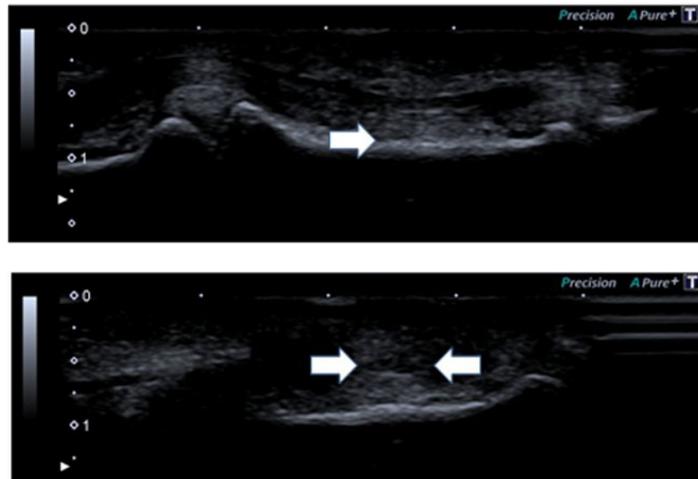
2 years postoperative Ultrasound, single arrow displaying E-Space of 0mm, double arrow showing width of the graft as well as slim appearance
